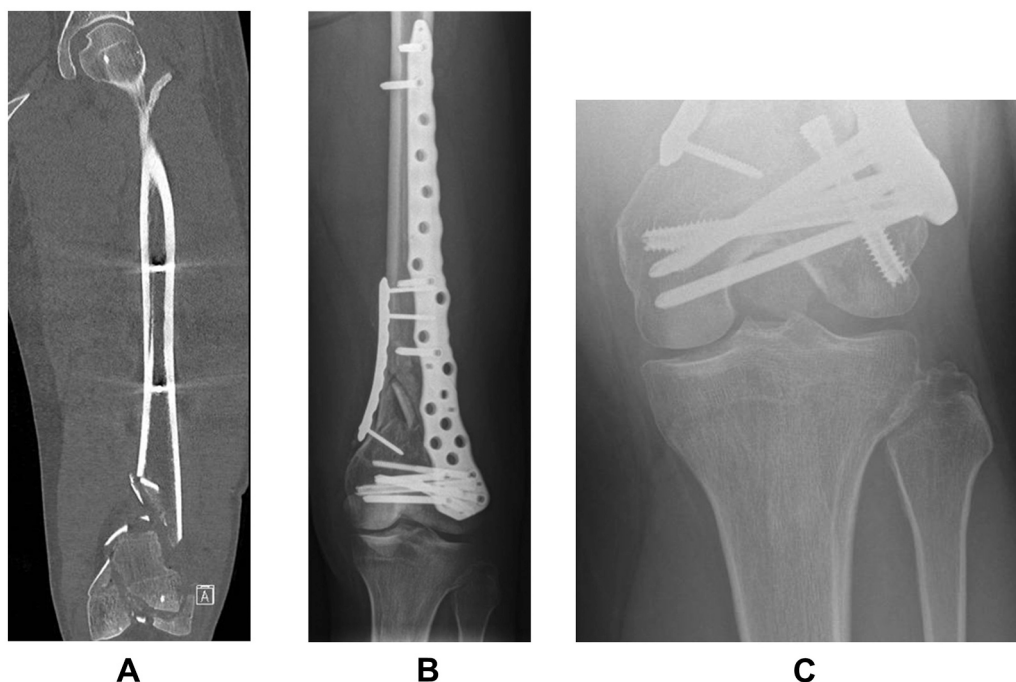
Panel A: Coronal CT-view of left femoral fracture.
